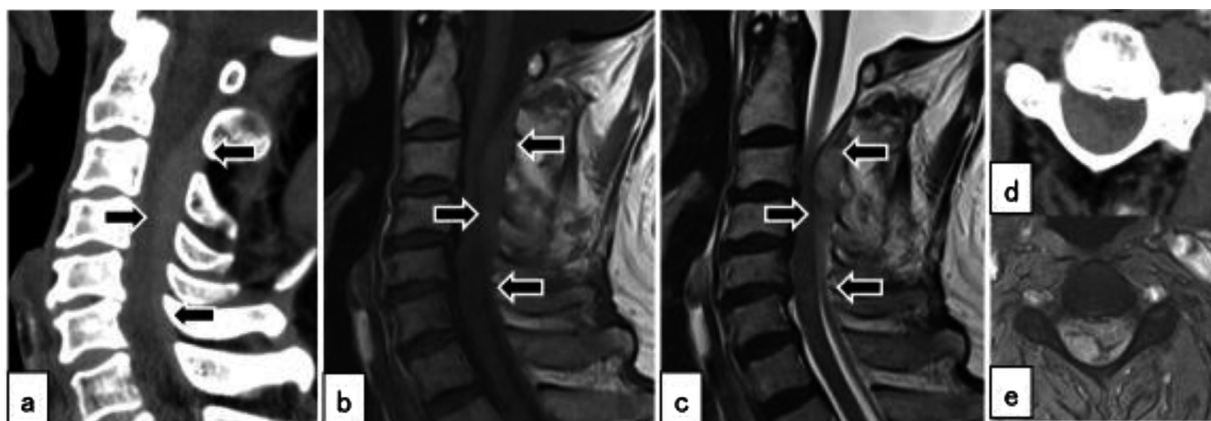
Case 9. (a, d) Computed tomography scan with soft tissue window settings showing a spindle-shaped mass lesion suspicious for hematoma at the C2–C6 level (arrows). (b, c, e) Spontaneous spinal epidural hematoma was diagnosed with magnetic resonance imaging, and surgical treatment was performed in the patient (arrows).
